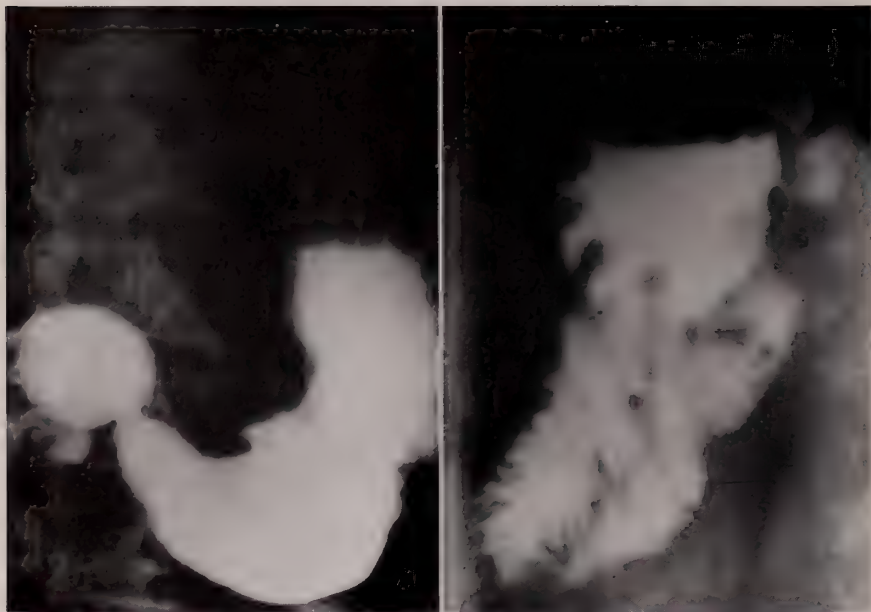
Case 2. X-ray demonstrating the large gastric ulcer on the lesser curvature and the normal duodenal bulb.
